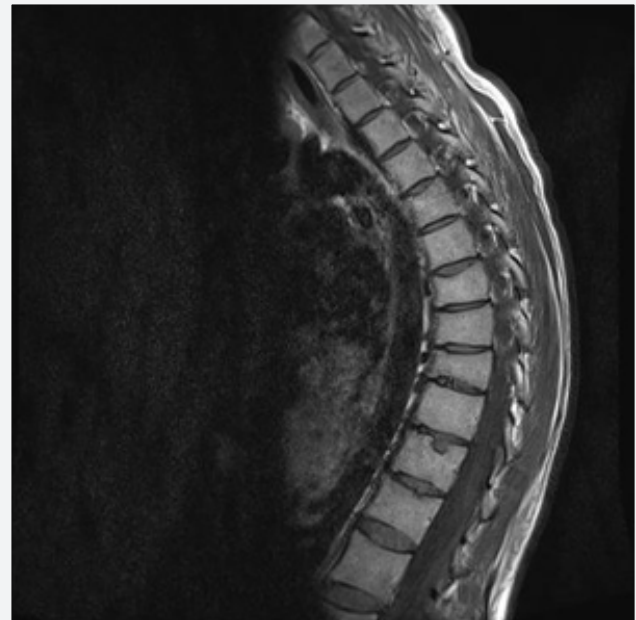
T2 sagittal magnetic resonance imaging at the end of two years
